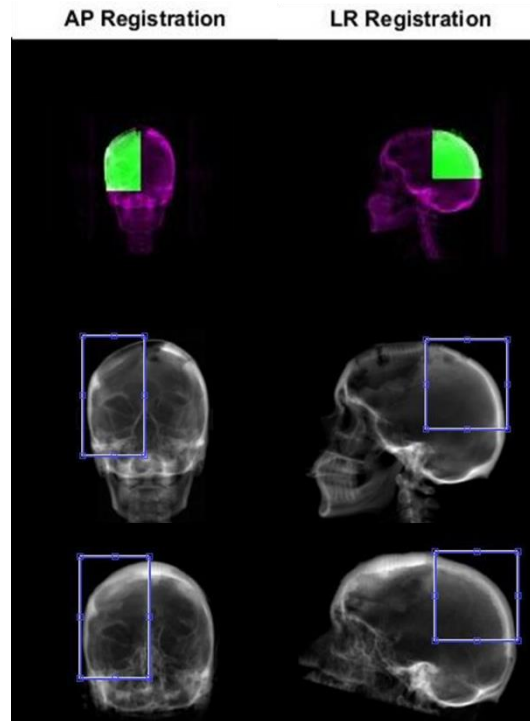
(Top) Registration overlays for patient 2, and corresponding (middle) A-P and lateral CT DRRs and (bottom) synCT DRRs
